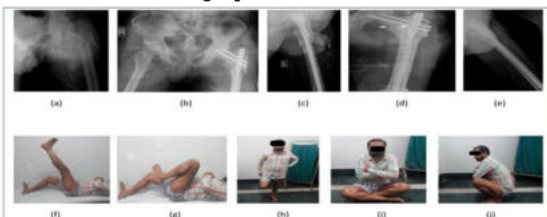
a- Radiograph of left hip showing AO31A3.1 fracture.
